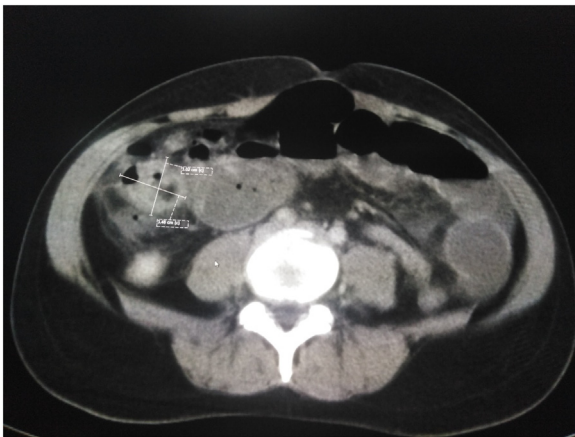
Axial image of contrast enhanced CT abdomen. An oval shaped structure with thickened enhancing mural wall at the sub-hepatic region measuring 3 × 3.4 cm in antero-posterior and transverse diameters associated with surrounding mesenteric fat stranding and few enlarged lymph nodes.
